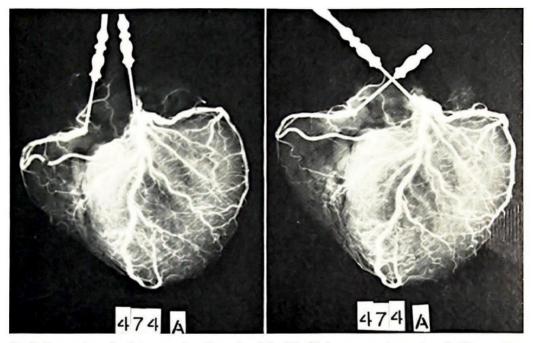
Represent a pair of stereoscopic radiographs of the fully filled coronary artery system. In this case, the whole coronary artery system was filled by injecting the left coronary artery alone. This is classified as a case with complete intercoronary anastomoses (see Table 2). No pathology detected.
